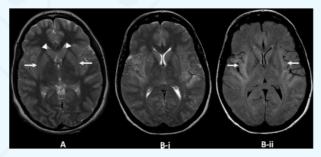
Claustrum changes on MR in two adult patients from the King's College Hospital new-onset refractory status epilepticus database. (A) Axial T2-weighted image, patient 1: there is faint T2 high signal in the claustrum on both sides (arrows) with faint T2 high signal and slight swelling in both caudate nuclei (arrowheads). (B) Axial T2-weighted (i) and fluid-attenuated inversion recovery (ii) images, patient 2. There is T2 high signal involving the claustrum, external capsule and insula and temporal opercula on both sides (arrows). Image courtesy Dr Jo Jarosz, King's College Hospital.
